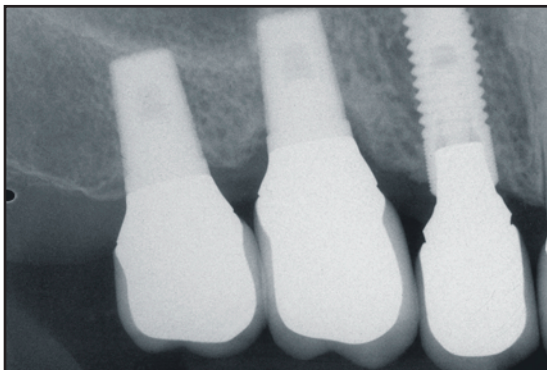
Five-month periapical radiograph of individual implant-supported restorations at sites #2, #3, and #4.
